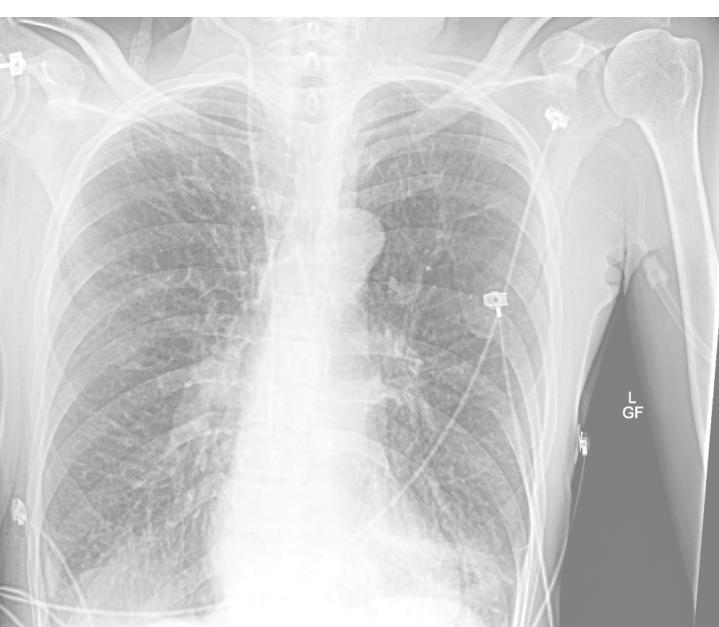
Chest x-ray of patient immediately following surgery indicates coarse opacities in both lungs. COPD is likely. Subsegmental atelectasis is present. CVL is seen in R IJ. No pneumothorax is present.
